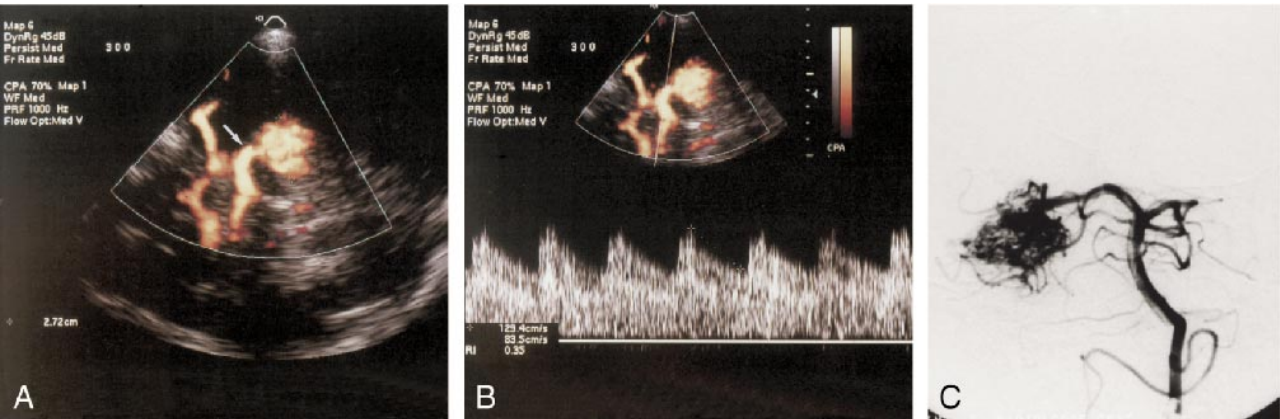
A, EE-TCD shows an AVM with a diameter of 2.7 cm. The lesion is fed by the right PCA (arrow). B, In the duplex mode, a high PSV (129.4 cm/s) and a low RI (35%) can be detected, indicating low vascular resistance. C, Angiogram after catheterization of the left vertebral artery confirms the sonographic diagnosis.
